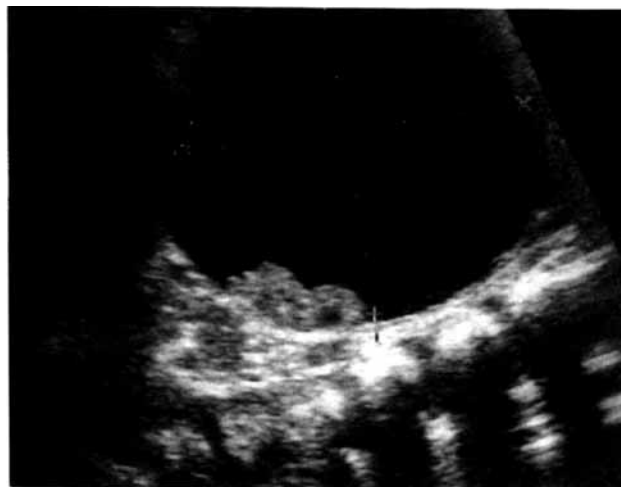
Preoperatively ultrasound shows cystic abdominal lesion mistakenly diagnosed as mesenteric cyst.
